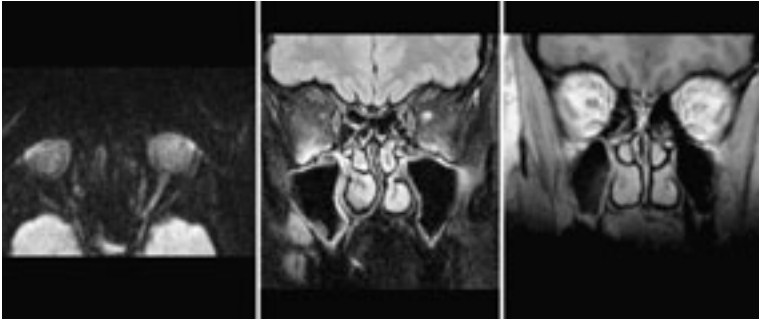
Left-sided optic neuritis as an initial manifestation of multiple sclerosis. Axial diffusion-weighted image (left) and coronal T2-weighted MR image (center) with fat and water suppression (SPIR FLAIR) show increased signal intensity of the optic nerve. Post-contrast coronal T1-weighted image (right) shows marked enhancement.
